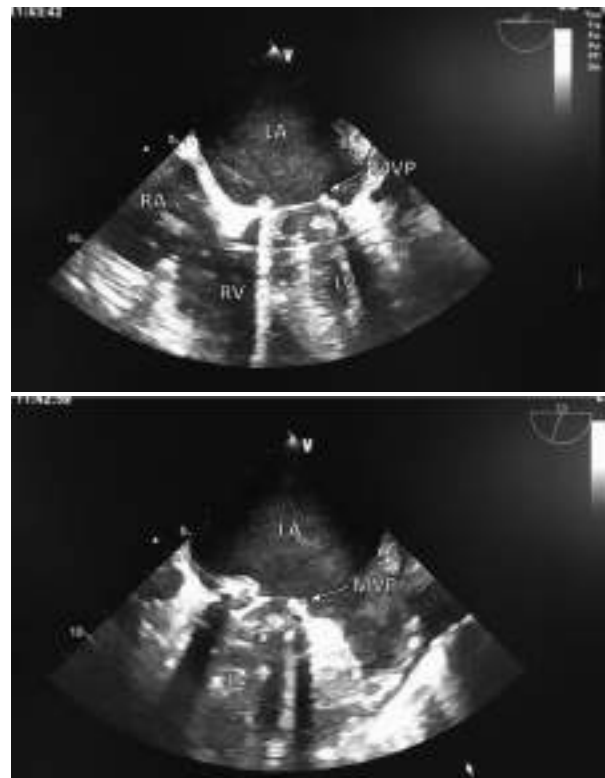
Transesophageal echocardiography of the prosthetic valve: thrombosis with multiple thrombi floating between the left ventricle and left atrium
